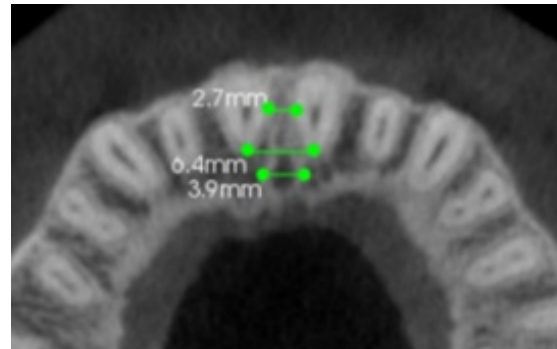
Transverse measurements in axial section of CBCT
